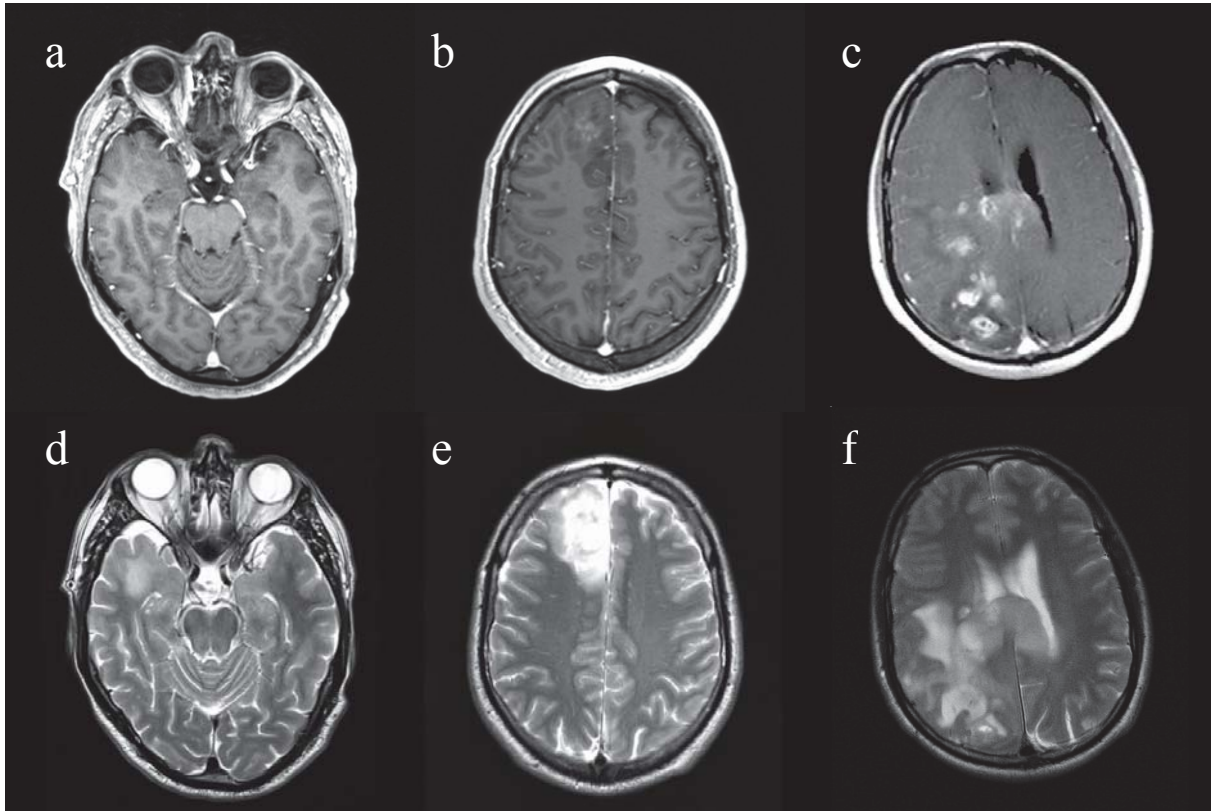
Comparison of imaging findings in a grade II glioma (a and d), a grade III glioma (b and e) and a GBM (c and f). Contrast-enhanced T1w MRI (a-c) and T2w MRI (d-f). No CE is seen in the grade II glioma (a), but some edema in the right temporal lobe is seen in the T2w images (b). In the WHO grade III glioma a patchy CE is seen in the right frontal lobe with surrounding edema (b). Large CE is seen in the T1w images of the GBM (c). The CE is highly heterogeneous with some lesions showing signs of cystic formation and necrosis. Images courtesy of Kyrre Emblem PhD, Department of Diagnostic Physics, Oslo University Hospital.
